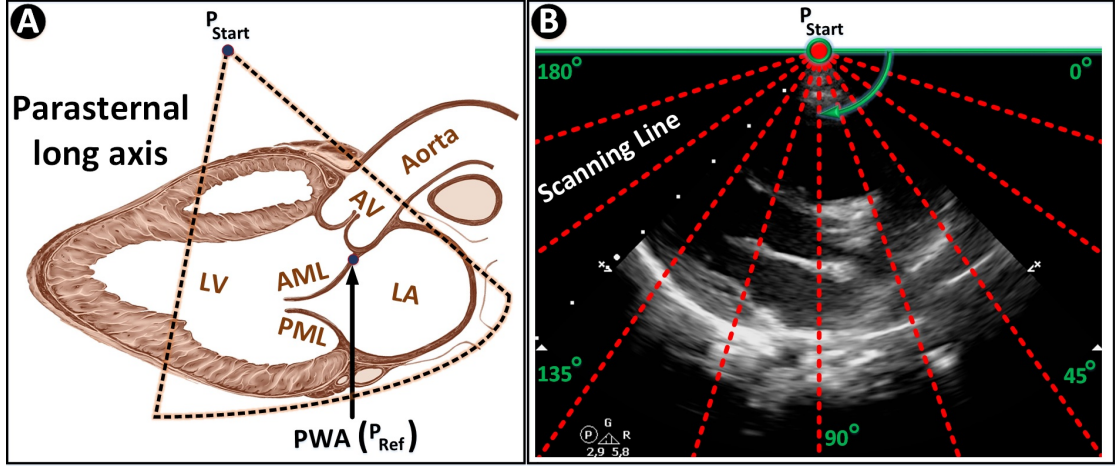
A) Parasternal long axis (PLAX) view (AML - Anterior Mitral Leaflet, PWA - Posterior Wall of the Aorta, P_{Start} - starting point of the ultrasound); B) PLAX view of the ultrasound image, origin point P_{Start} with respective angles and scanning lines.
